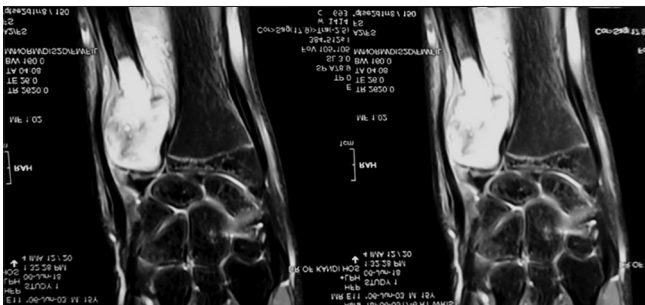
Magnetic resonance imaging showing an expansile lytic locally aggressive SOL of the distal ulna
